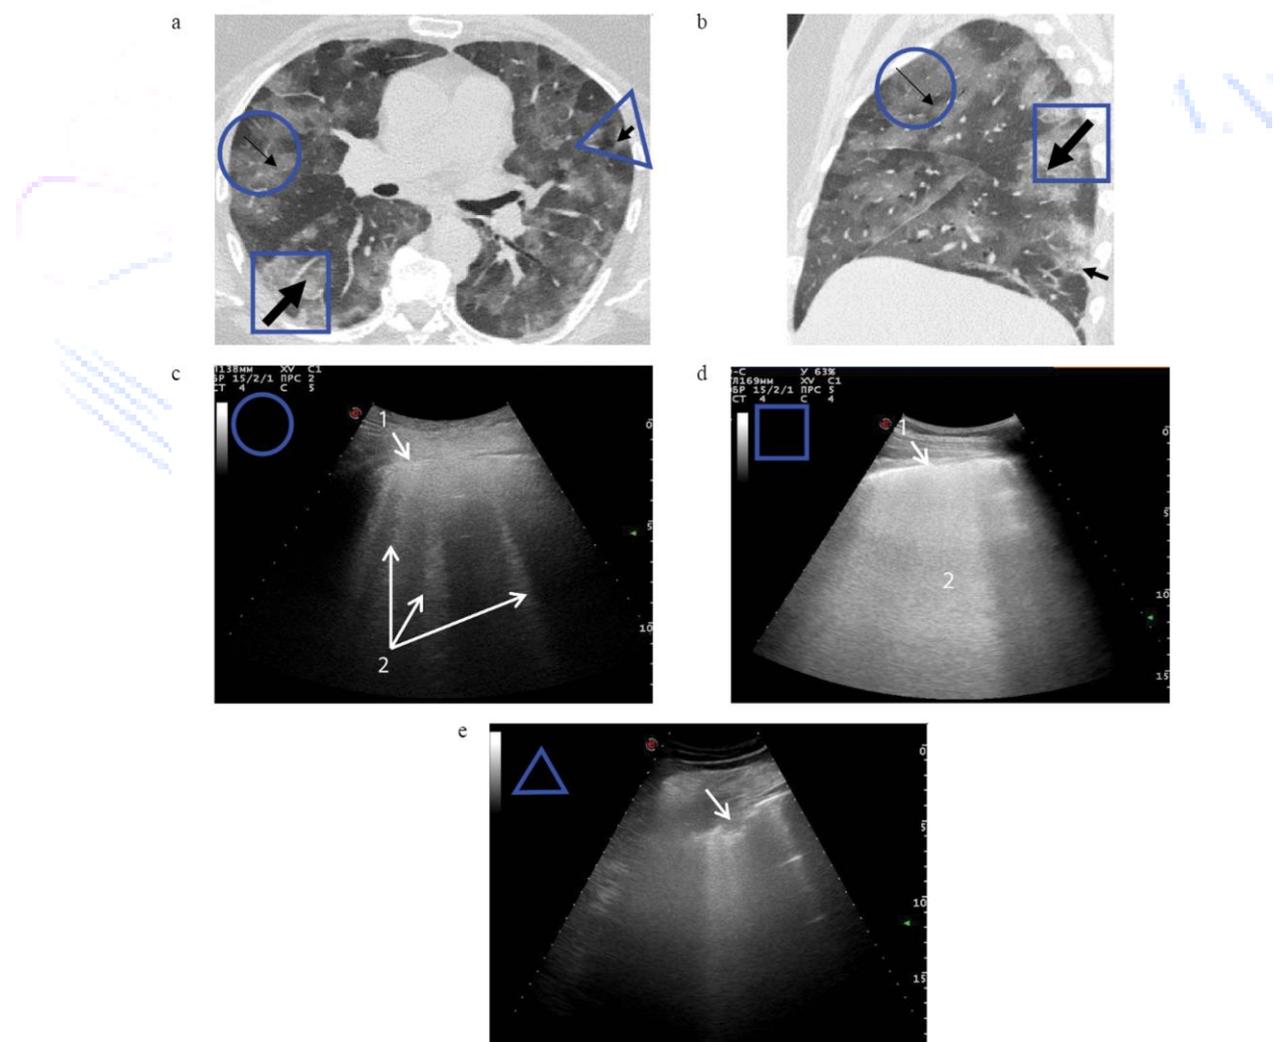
Computed tomography and echograms of the lungs of a 62-year-old man with COVID-19
